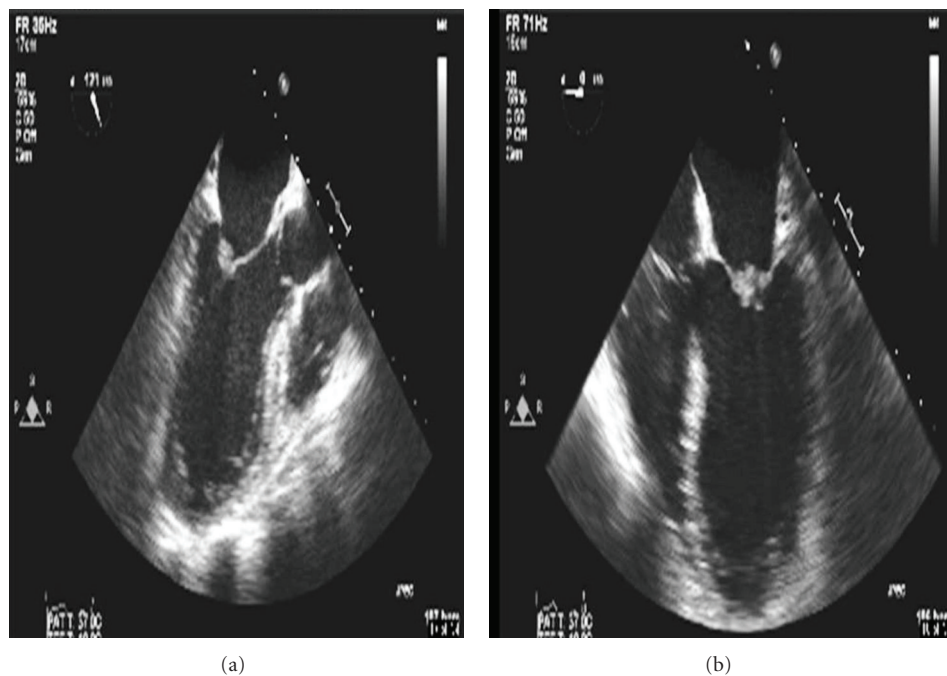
A transesophageal echocardiogram showing vegetation on the mitral valve.
